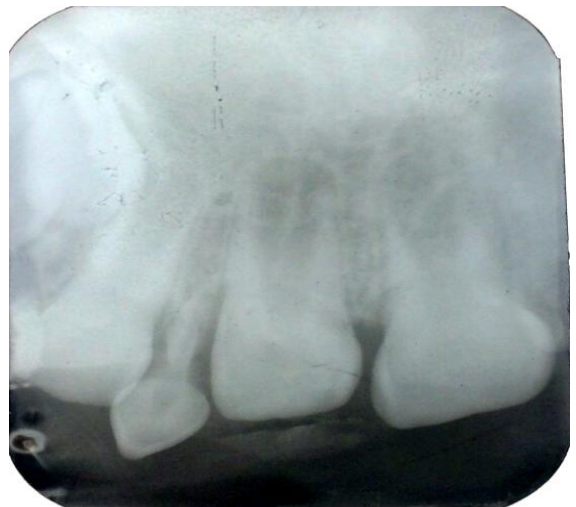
Intraoral periapical radiograph showing pericoronal shadow of soft tissue covering the erupting tooth and supernumerary tooth
